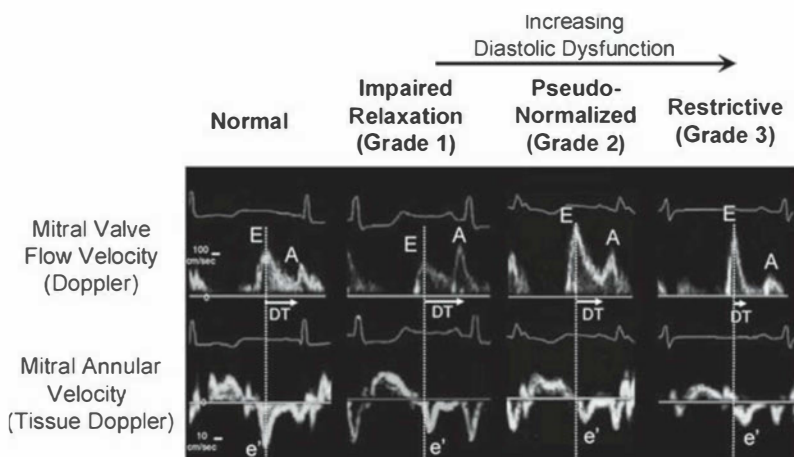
Restrictive filling pattern on transmitral Doppler echocardiography. Top panel: mitral valve flow velocity (Doppler); Bottom panel: mitral annular velocity (tissue Doppler); DT: deceleration time. (Used with permission from Little WC, Oh J. Echocardiography evaluation of diastolic function can be used to guide clinical care. *Circulation* 2009;120:803.)
